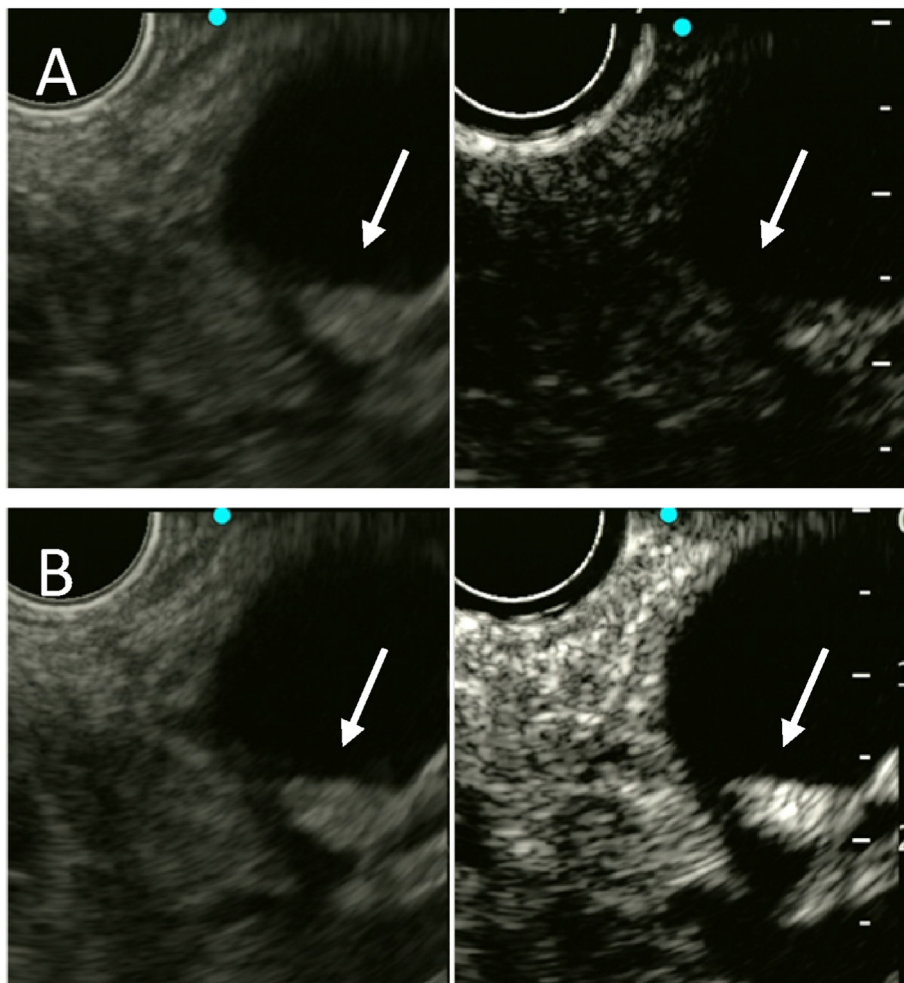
Mural nodule detected by endoscopic ultrasound.
